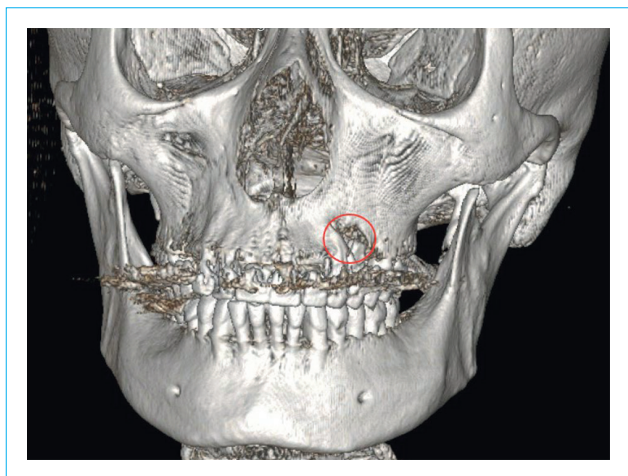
CT scan of the facial skull bones. Marked area: round-shaped bone thinning revealed in the 2.4, 2.5 teeth root area, – nidus of chronic infection
